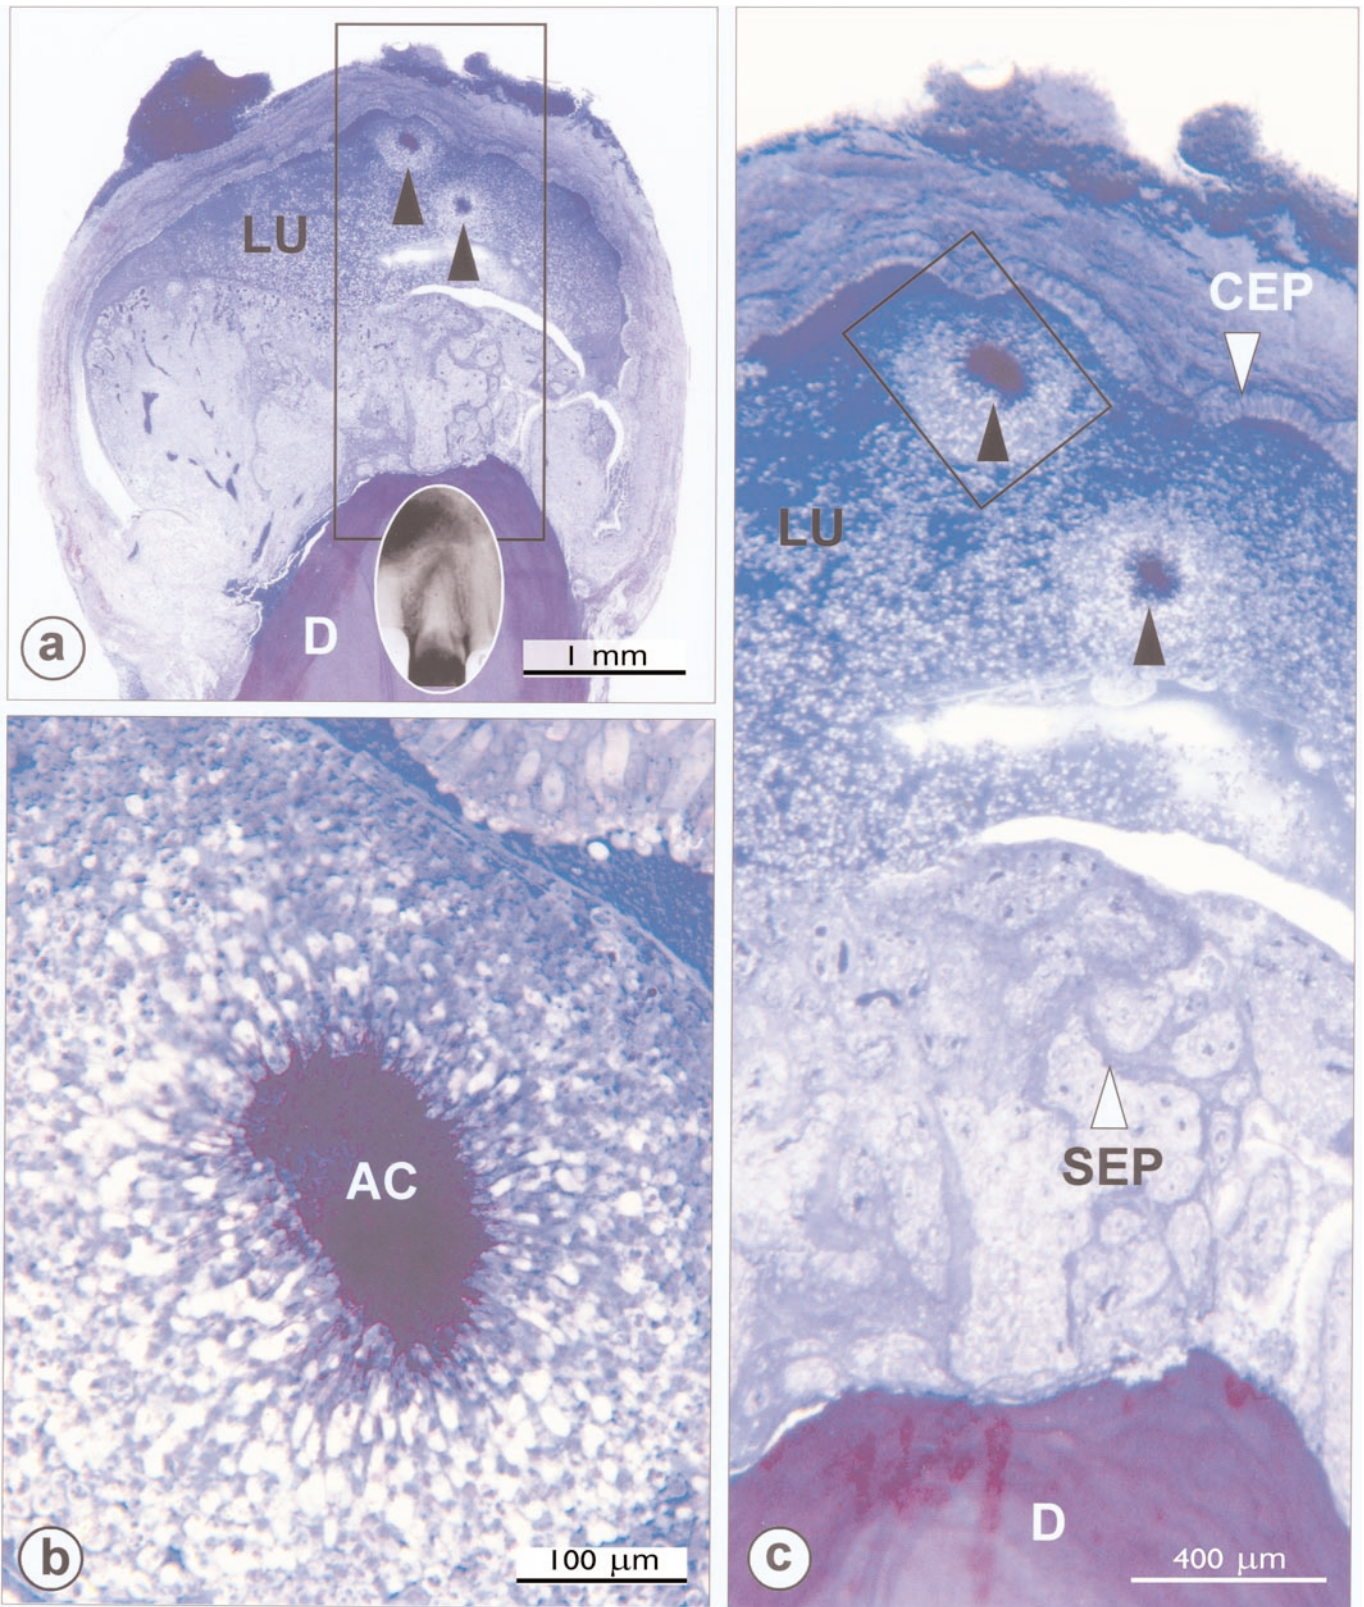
An *Actinomyces*-infected periapical pocket cyst affecting a human maxillary first premolar (radiographic inset). The cyst is lined with ciliated columnar (CEP) and stratified squamous (SEP) epithelia. The rectangular block in (a) is magnified in (c). The typical 'ray-fungus' type of actinomycotic colony (AC in b) is a magnification of the one demarcated in (c). Note the two black-arrowheaded, distinct actinomycotic colonies (AC in c) within the lumen (LU). Magnifications: (a) 20x, (b) 60x, and (c) 210x. (From Nair *et al.*, 2002.)
